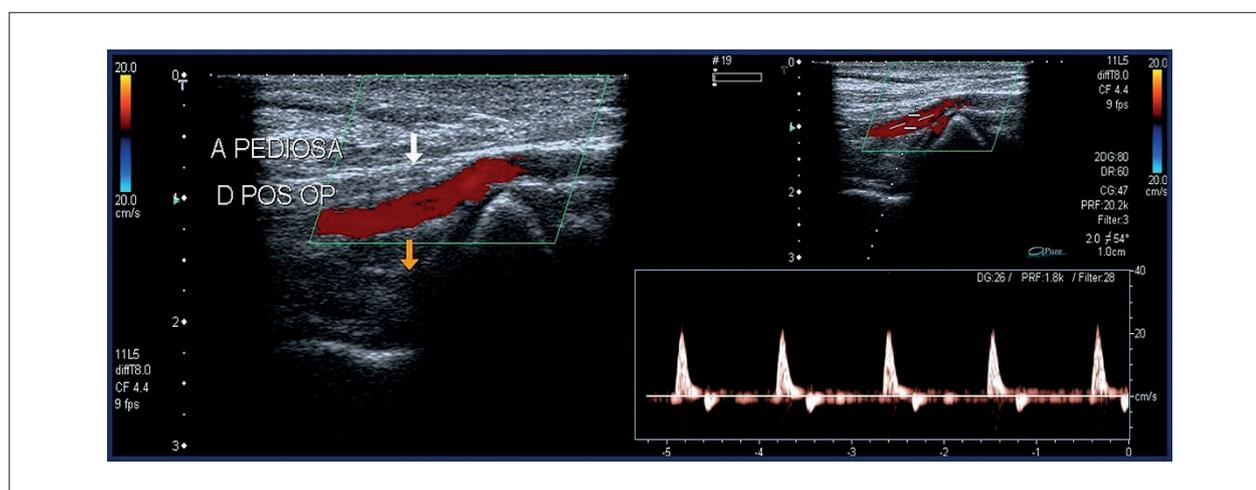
Postoperative control ultrasound. A: absence of aneurysm and arterial patency with preserved flow on color Doppler; B: multiphasic flow in the dorsalis pedis artery via spectral Doppler.
